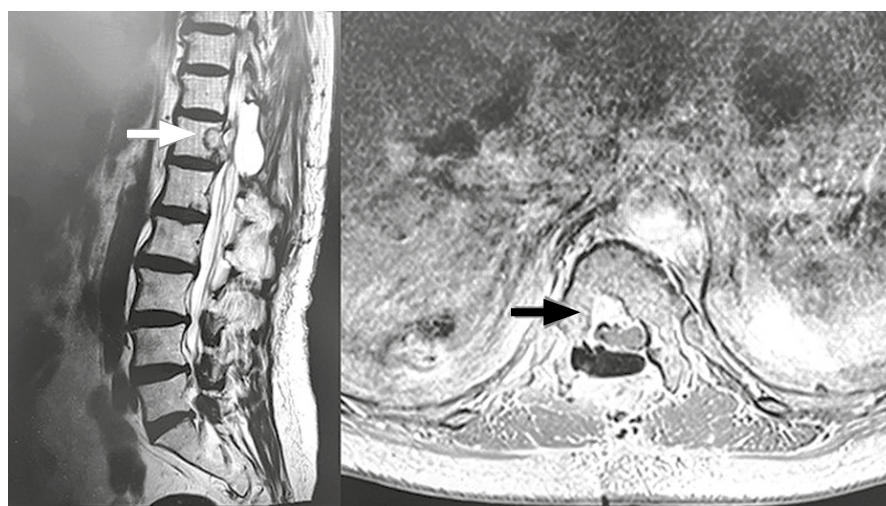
MRI of the spine 2 months after surgery, T1 mode (residual tumor in Th12).
